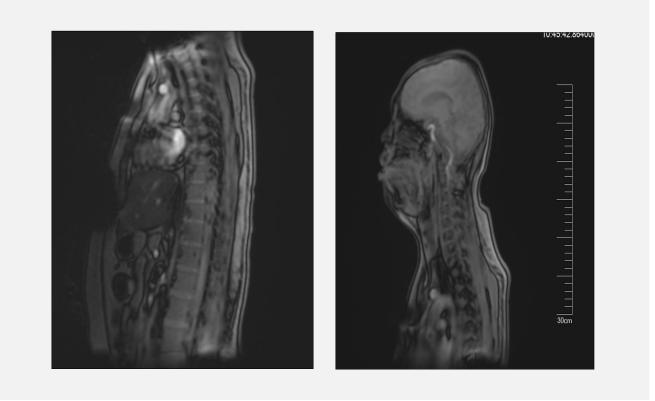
Magnetic resonance imaging (MRI) revealed an irregular mass at the left paravertebral region from T7 to T10, and intradurally, posterior to the spinal cord from T8 to T10: findings consistent with hematologic malignancy.
